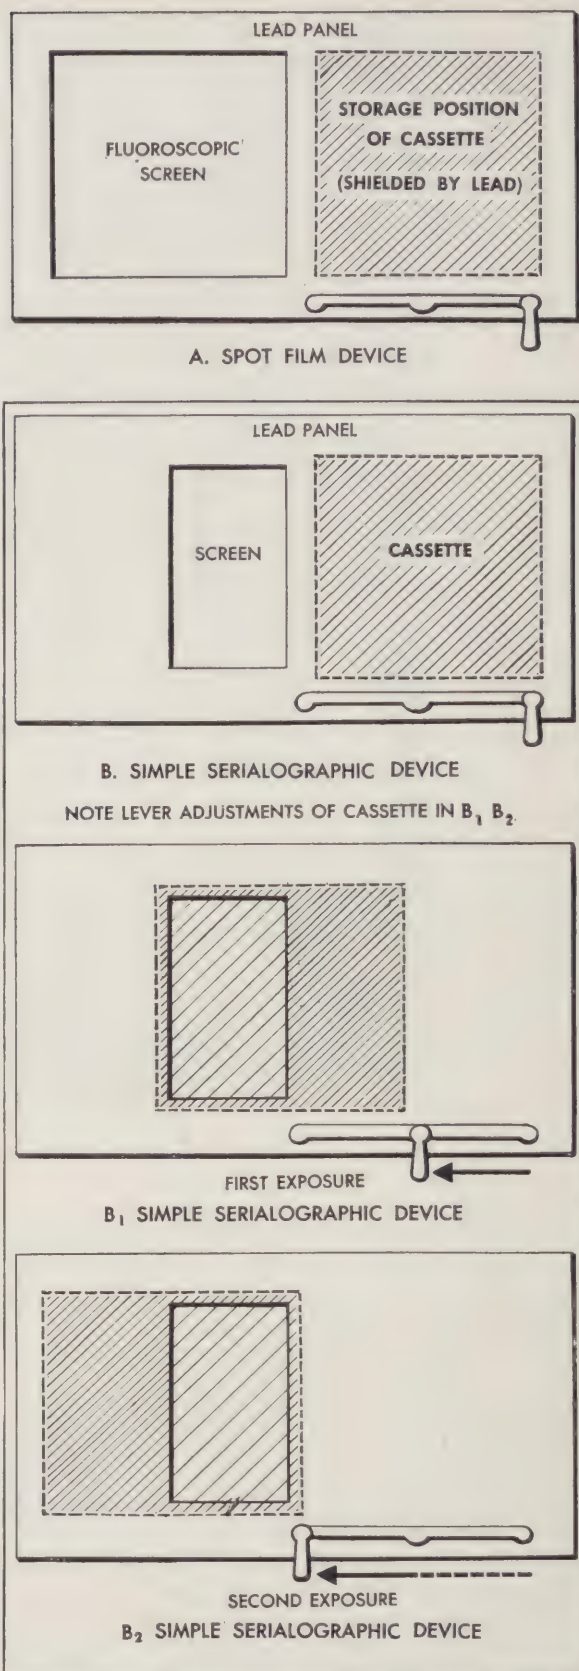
Spot-film roentgenography and serialography.
